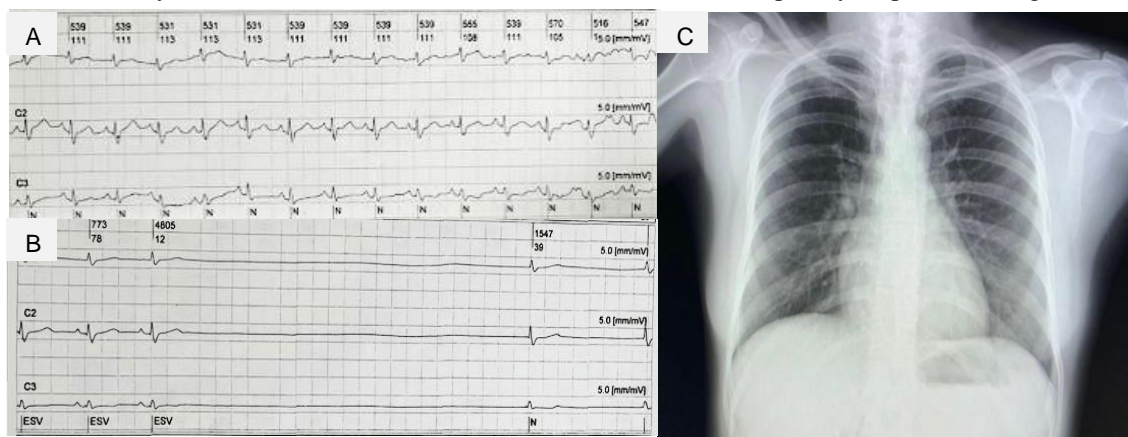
(A, B) Holter showing sinus tachycardia of 135 bpm alternating with sinus pause of 4.8-5.4 seconds, leading to a rate of 25 bpm (C) Chest X-ray with increased pulmonary hila, normal cardiac silhouette, and arches horizontal ribs.
